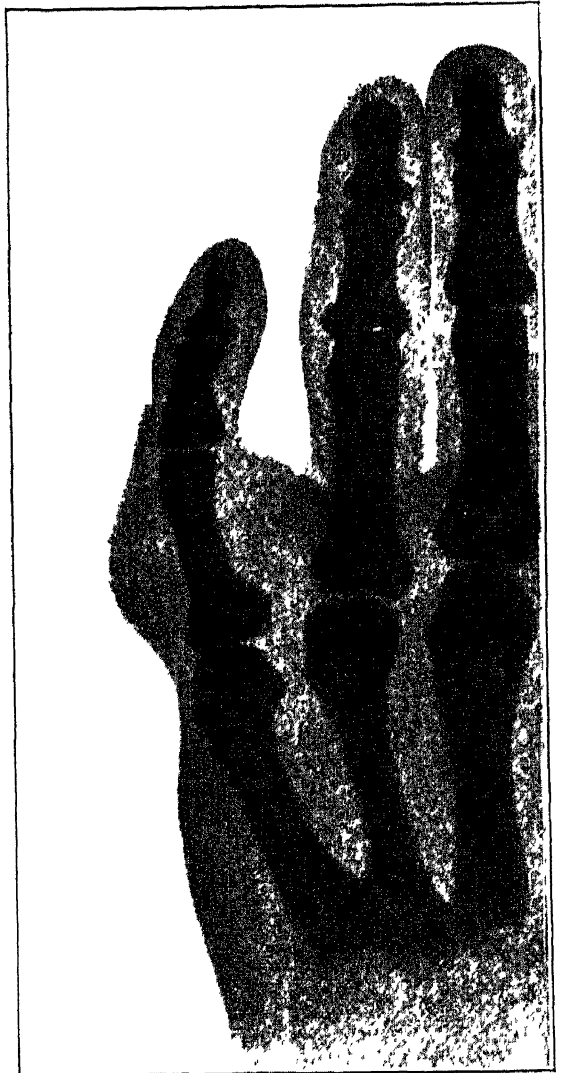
RADIOGRAPH OF FIBROLIPOMA
